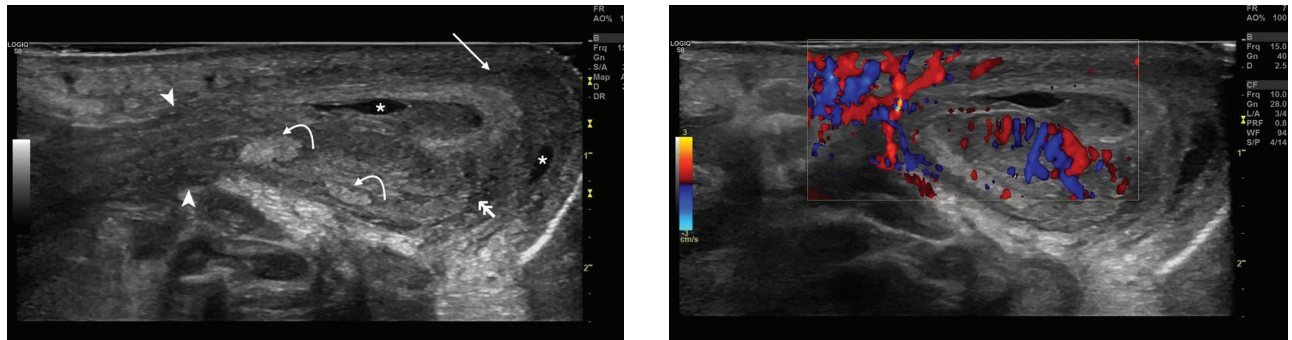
Complicated Amyand's hernia. a. Longitudinal gray-scale US of the inguinal canal and the scrotum demonstrates dilation of the deep inguinal canal (space between arrowheads). The scrotum contains heterogeneous tissues (double arrowhead), small fluid collections (asterisks), echogenic fat (curved arrows) consistent with intrascrotal fat necrosis and remarkable soft tissue edema (arrow). b. Same image with colour Doppler depicts markedly edematous and hyperemic tissues.
